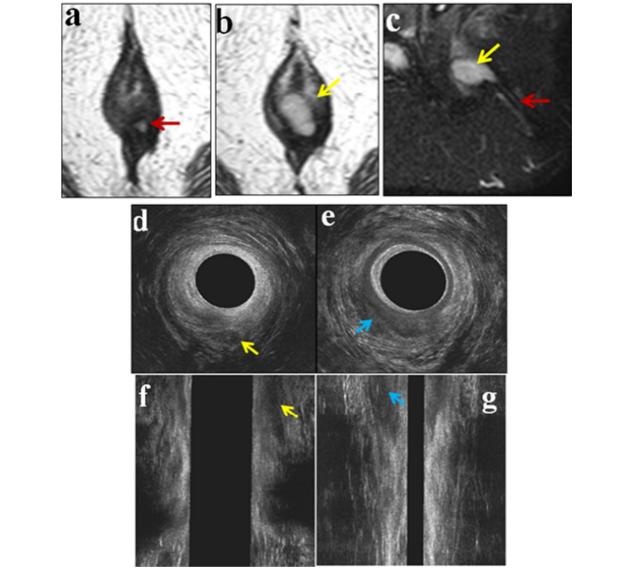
a, b, c MRI axial T2 and sagittal STIR WI images show left posterior high trans-sphincteric fistulous tract (red arrows) seen crossing the midline at the level of deep portion of external anal sphincter ending in right inter-sphincteric collection between 6–9 o'clock eliciting high T2&STIR signal (yellow arrows). d, f ultrasound axial and post reconstruction coronal images show left posterior high trans-sphincteric hypoechoic fistulous tract (yellow arrows) seen breaching the deep portion of the external anal sphincter and ending in right posterior and midline hypoechoic collection e, g with internal echogenic foci between 6–9 o'clock (blue arrows) at the level of the right puborectalis muscle
